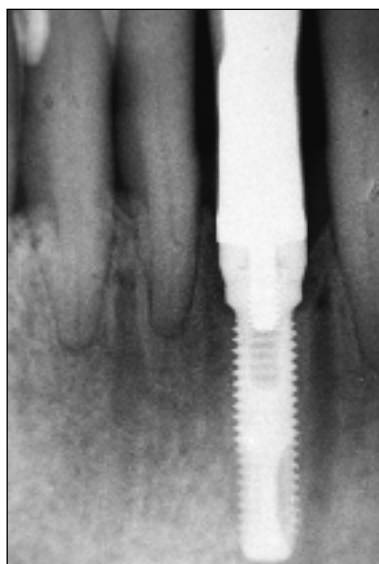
Radiograph of the new mandibular implant/abutment/crown interface, which has been in place for more than 4 years. The radiograph clearly shows the reduced periodontal support of the neighboring teeth, which could explain why the original crown became overloaded and dislocated. This choice of treatment can be debated, since there were other treatment options that might have seemed more appropriate at the time. The major reason for choosing implant treatment was that this was what the patient wanted. This treatment has also proven to be beneficial if one considers the fact that before treatment all other incisors presented a grade 2 mobility, and that the actual mobility of the neighboring teeth after 6 years of treatment was no more than grade 1.
